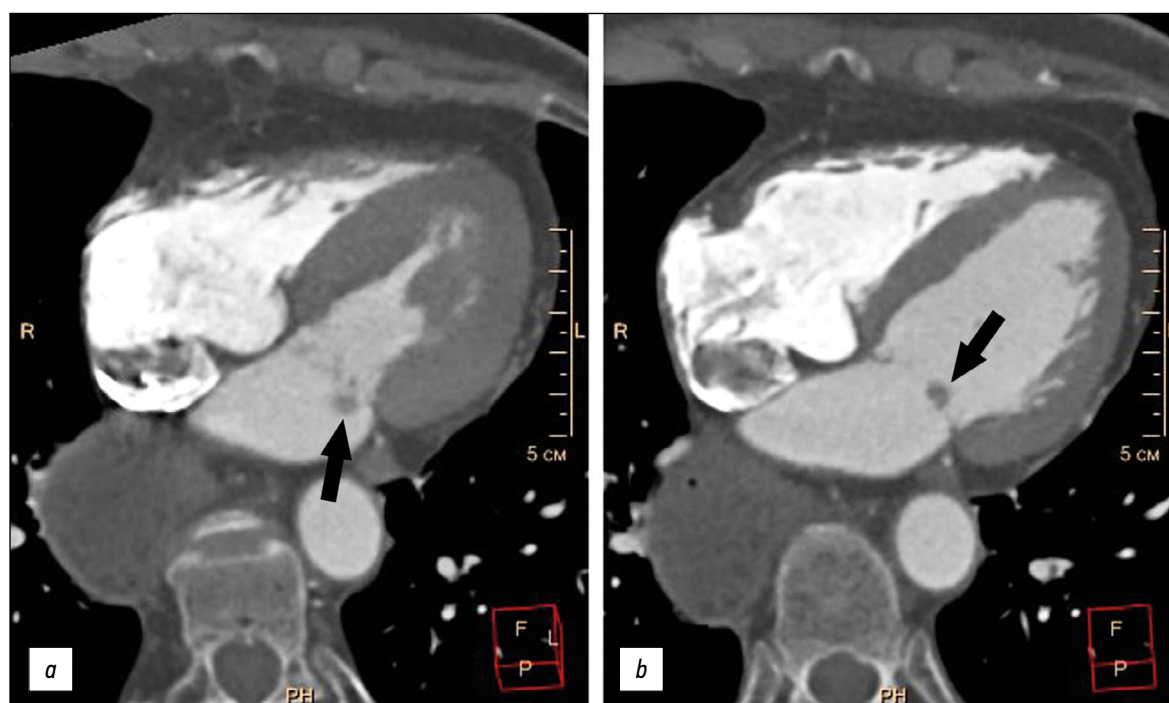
Multispiral computed tomography of thoracic organs, four-chamber planar heart reconstruction, arterial contrast phase: *a*, left ventricular systolic phase; *b*, left ventricular diastolic phase. Additional rounded structure on the posterior mitral valve leaflet (black arrows).
